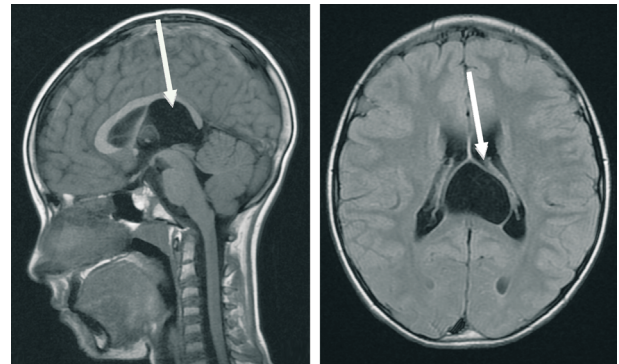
Cyst of the CVI seen on brain MRI CVI: Cavum of the velum interpositum; MRI: Magnetic resonance imaging.
